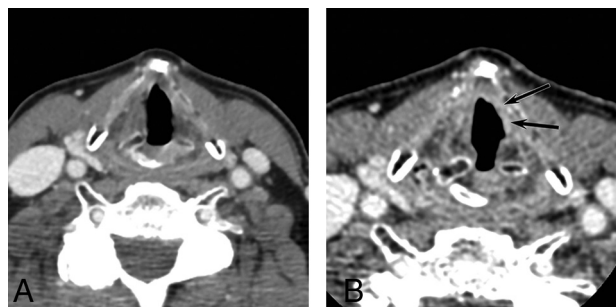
Axial CT images of a 65-year-old man with squamous cell carcinoma of the left true vocal cord. Standard 2.5-mm neck image (A) was interpreted as having normal findings. On a dedicated 1-mm larynx protocol image (B), the ulcerated enhancing tumor along the true vocal cord (arrows) was evident.
